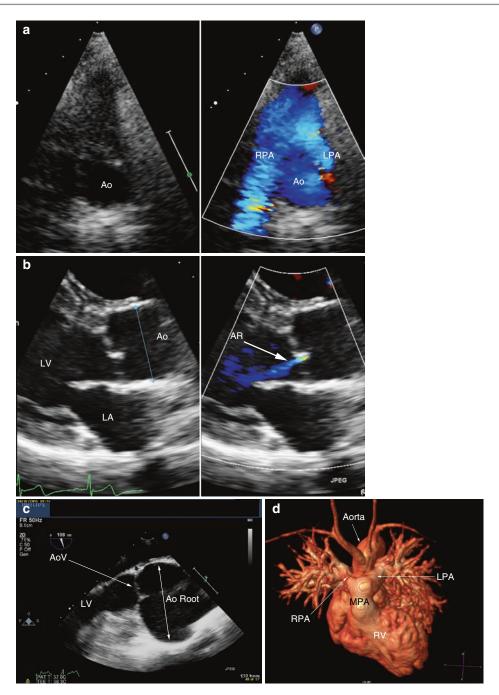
Transposition of the great arteries following the arterial switch operation. (a) High parasternal short-axis showing the branch pulmonary arteries positioned anteriorly to the aorta following the Lecompte Manoeuvre during the arterial switch operation. In larger patients it becomes difficult to see the branch pulmonary arteries which are better appreciated with the use of colour flow Doppler. (b) Parasternal long axis view of adolescent patient following an arterial switch operation. There is mild central aortic regurgitation. The aortic annulus is dilated as is the aortic root (38 mm, marked by calipers)
